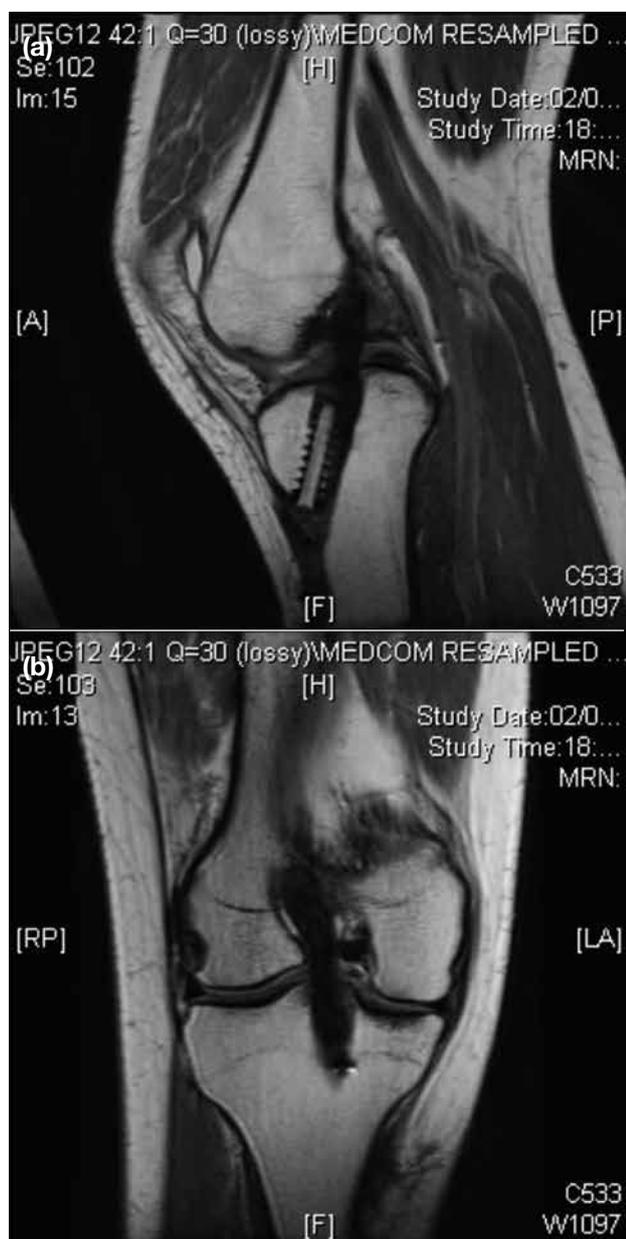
Intact anterior cruciate ligament graft in a 34-year-old woman. Sagittal (a) and coronal (b) proton density-weighted magnetic resonance images showing homogeneous low signal intensity throughout the anterior cruciate ligament graft.
